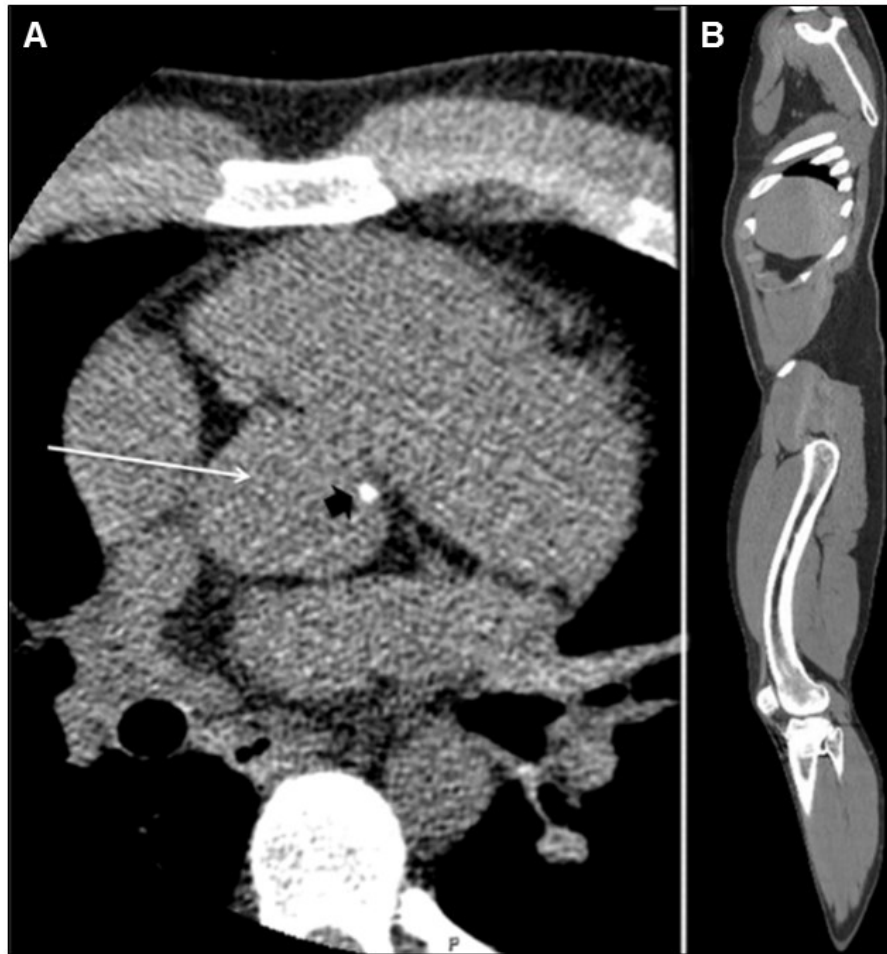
Imaging of patient with GACI. (A) CT revealed minimal calcification in the aortic root. (B) Anterior bowing of the legs.
